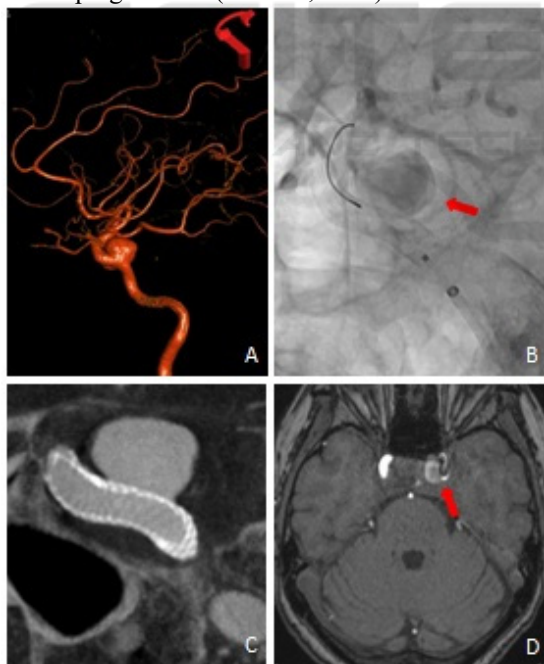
A. Cavernous carotid aneurysm showed by 3D angiography. B. Immediate angiography post flow diverter placement showed stasis of contrast within aneurysm sac. C. CT showed good position of device. D. Axial TOF MRI after oneweek treatment showed trombosis in aneurysm sac.
